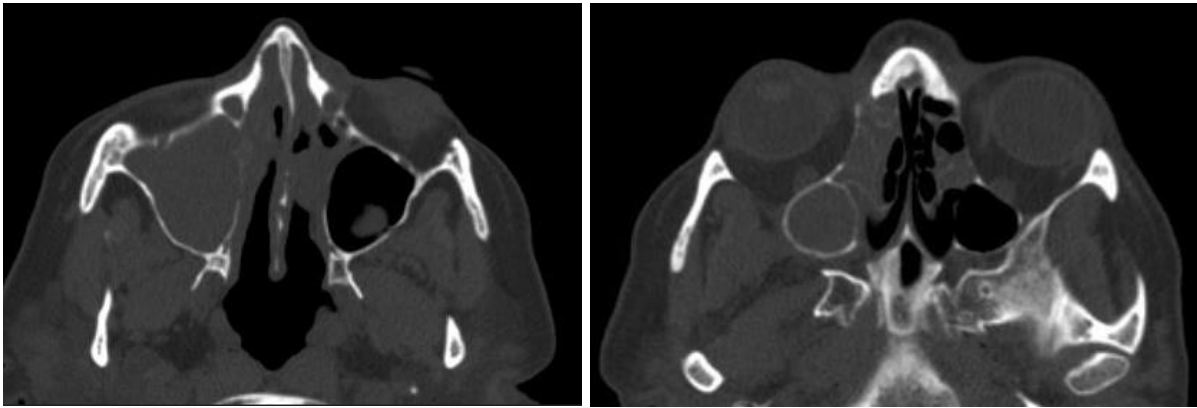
Axial section of a facial CT scan in a bone window showing thinning of the internal walls of the maxillary sinuses, nasal septum, and ethmoidal labyrinth, with areas of bone destruction.
